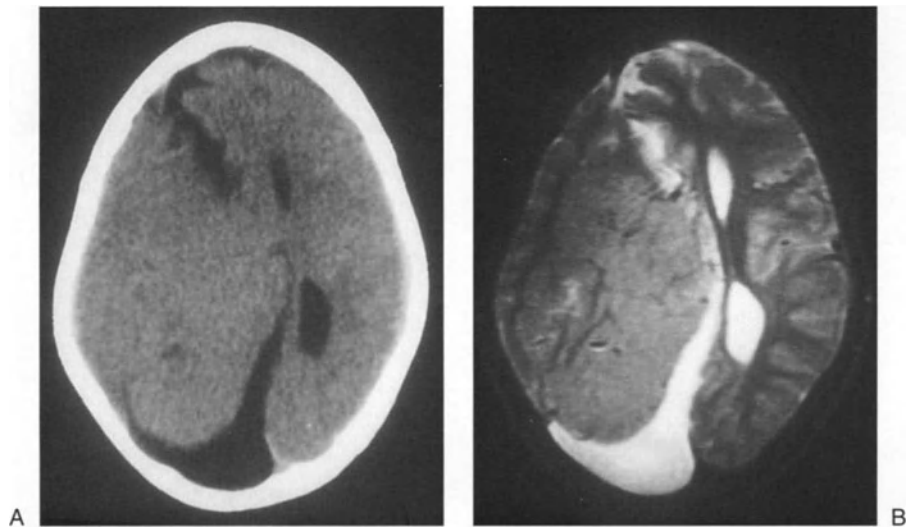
Agenesis of the corpus callosum and migration defect. These [T1 (A) and T2 (B) weighted MRI] images reveal the very characteristic changes of migration defect in the right cerebral hemisphere with an apparently normal, though markedly compressed, left hemisphere.
